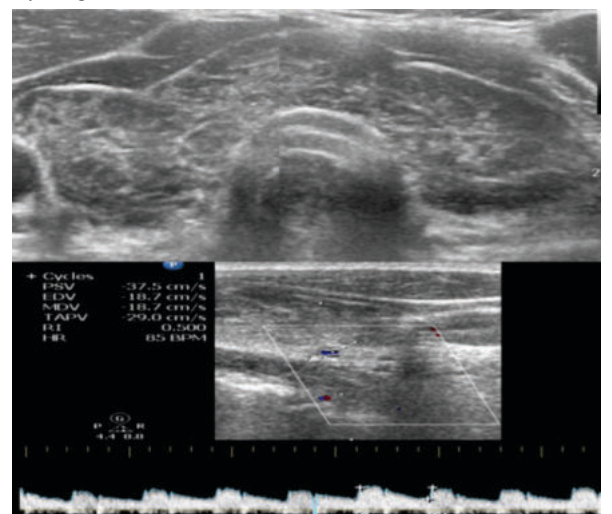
Gray scale appearance and Doppler evaluation of thyroid
